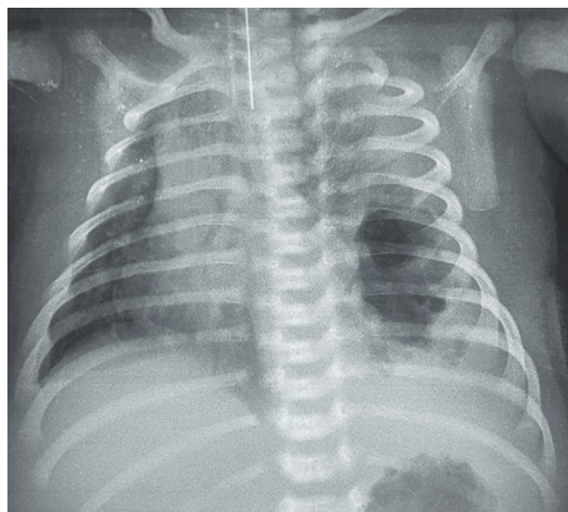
Plain film of the chest. Left pleural effusion and multicystic air-filled lesion at left pulmonary lower lobe with mediastinal shift to the right and hypoexpansion of the lung; bilateral radiological signs of RDS.
